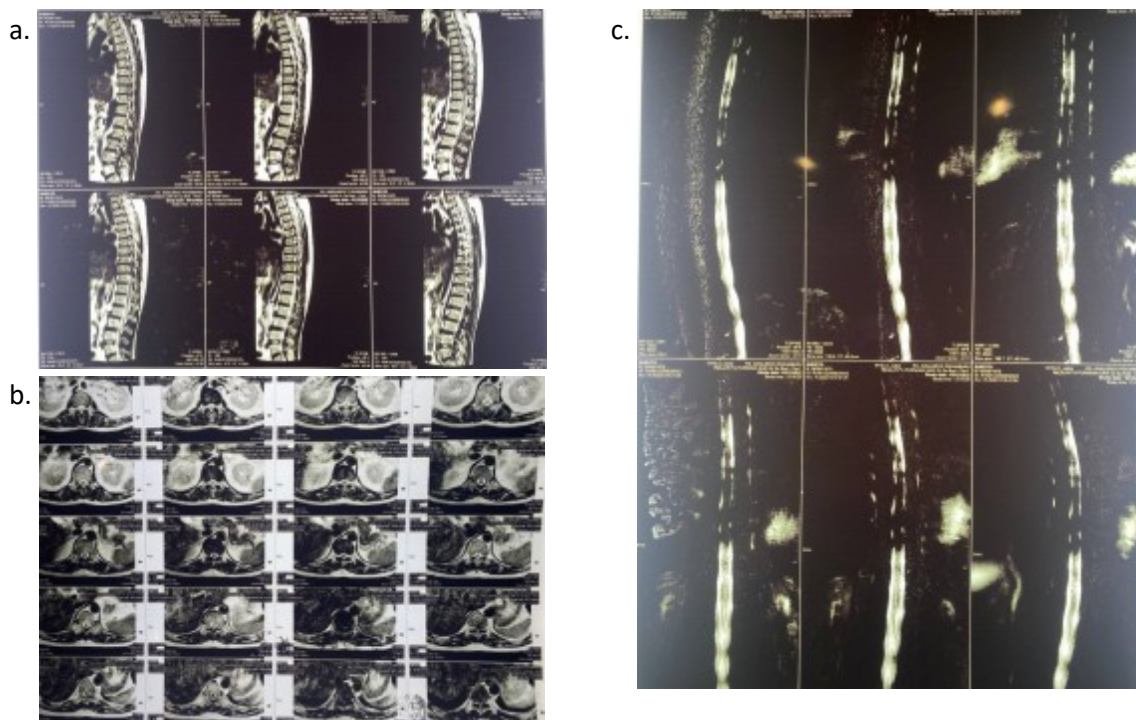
MRI of the spine showing (a) Sagittal, (b) Coronal, and (c) Myelography Sections.
